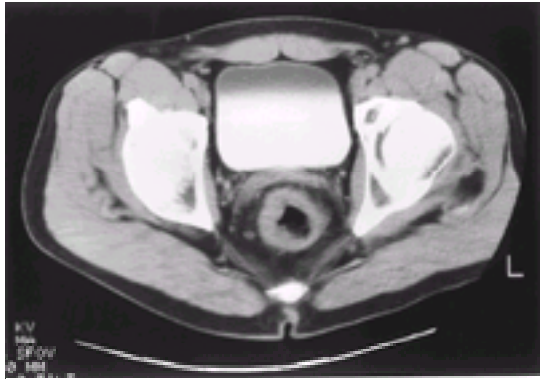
Pelvic CT scan indicating a rectal cancer with suspicion of pelvic nodal metastases.
